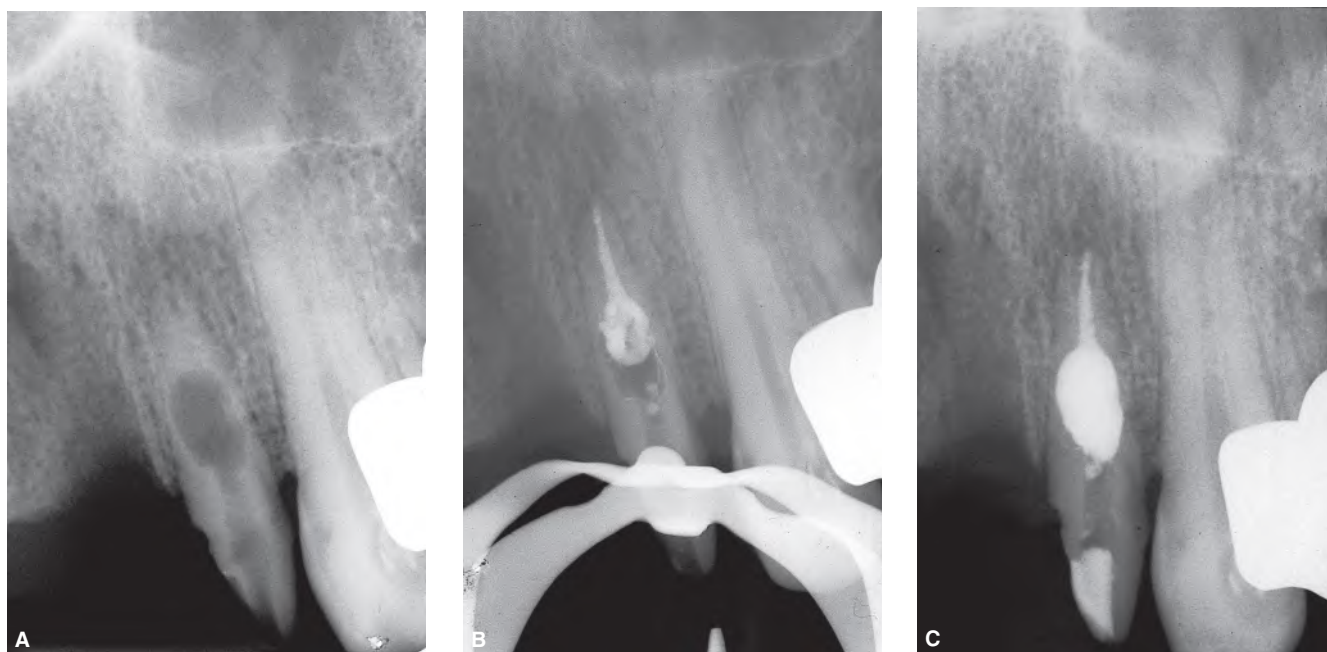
A. Preoperative radiograph of a maxillary left lateral incisor with a large internal resorption defect. Once this type of resorption is diagnosed, it is necessary to intervene immediately because the lesion tends to progress. B. Intraoperative radiograph of the apical condensation. C. Postoperative radiograph. The area of internal resorption has been filled with thermoplastic gutta-percha.
